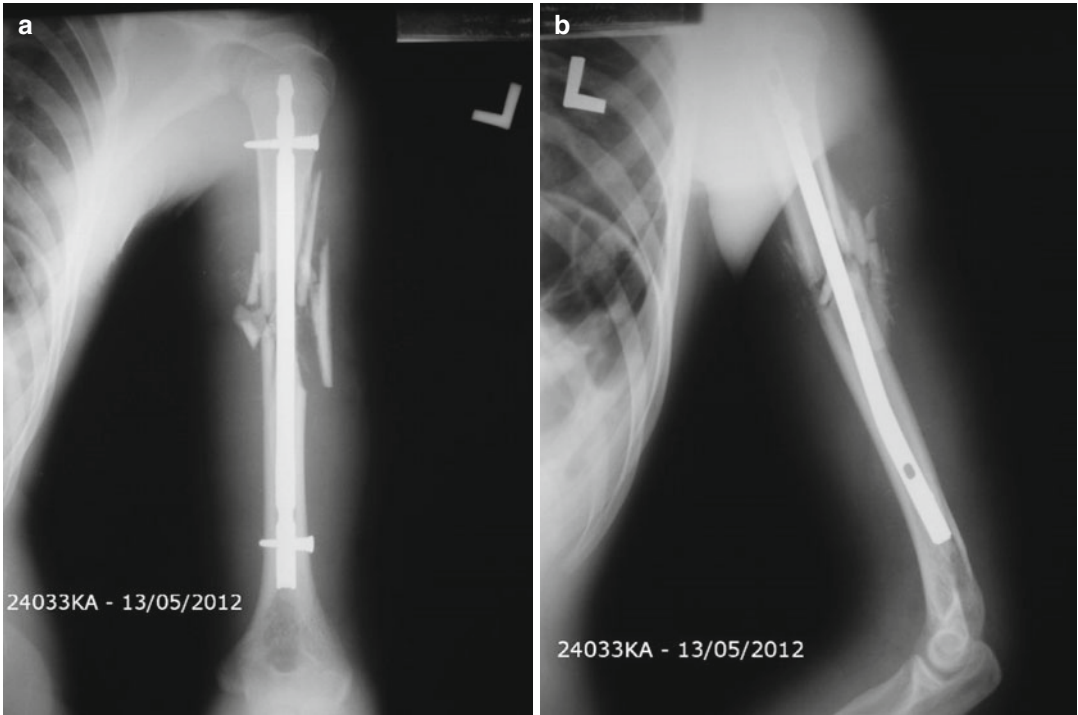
Postoperative (a) AP and (b) lateral X-rays of patient discussed in Case 1
